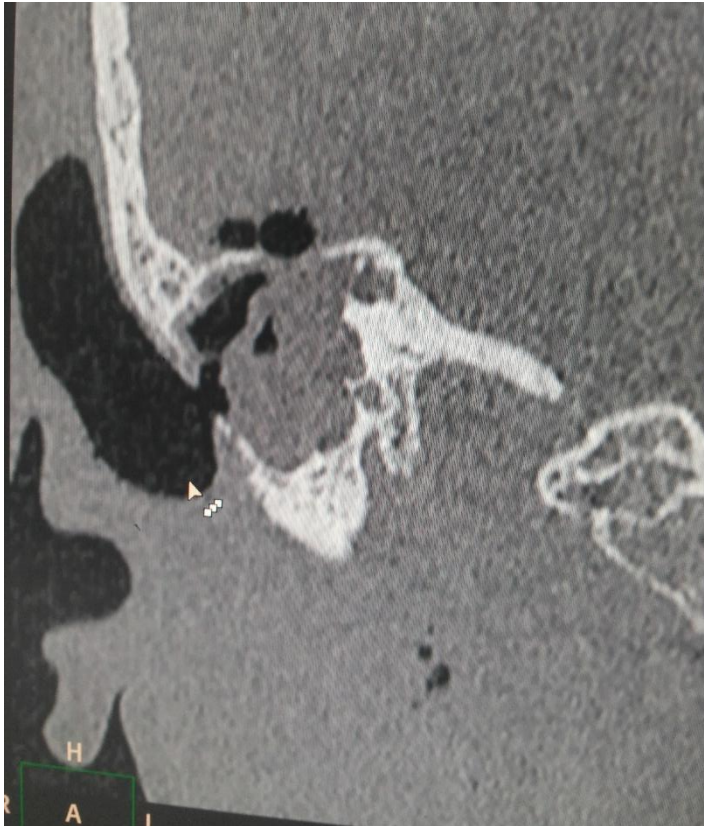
Axial and coronal HRCT shows destruction of the postero-superior wall of external auditory canal by adjacent cholesteatoma.
